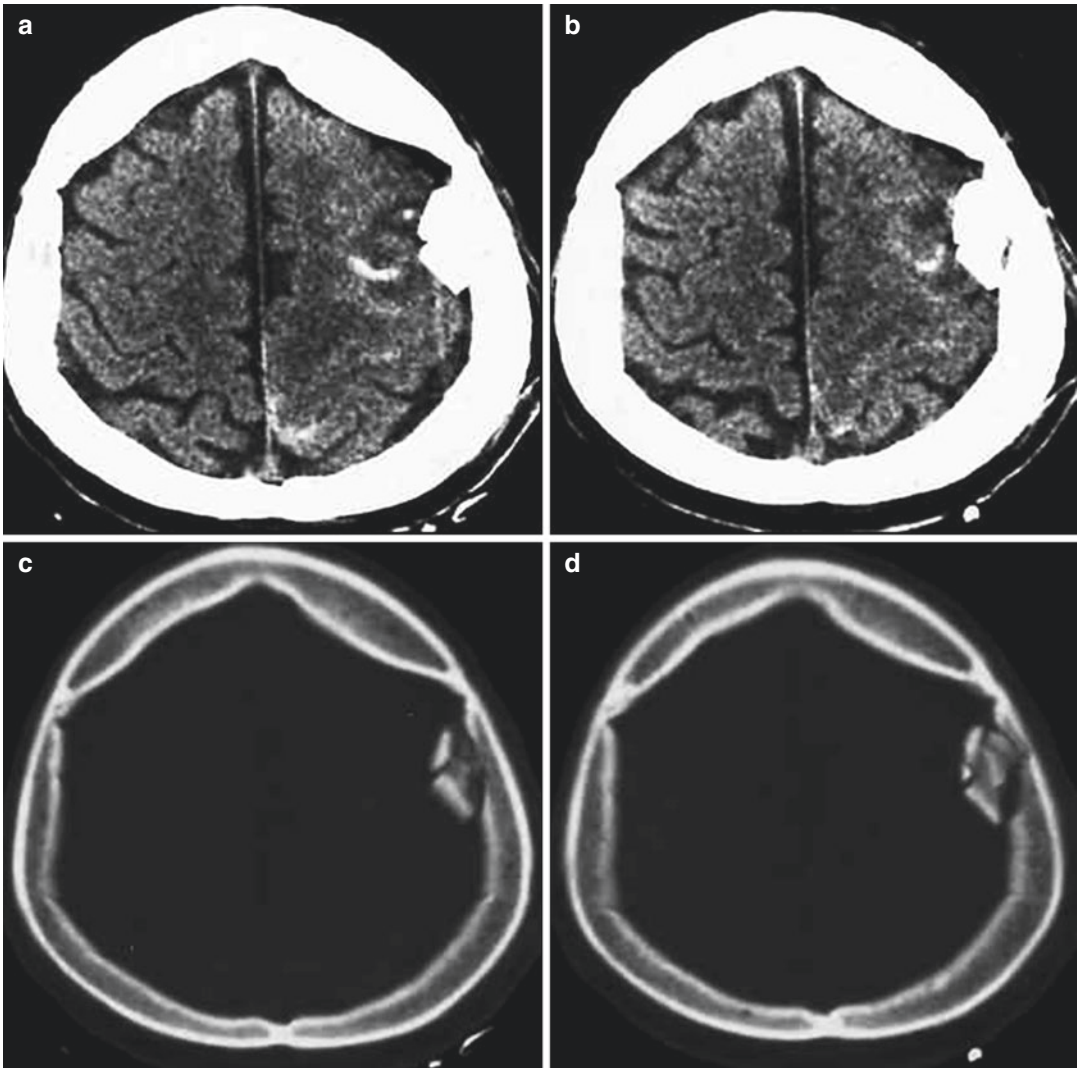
(a–d) CT scan. Subarachnoid hemorrhage: presence of linear hyperdensities within the left frontoparietal subarachnoid spaces, associated with a contiguous depressed fracture
